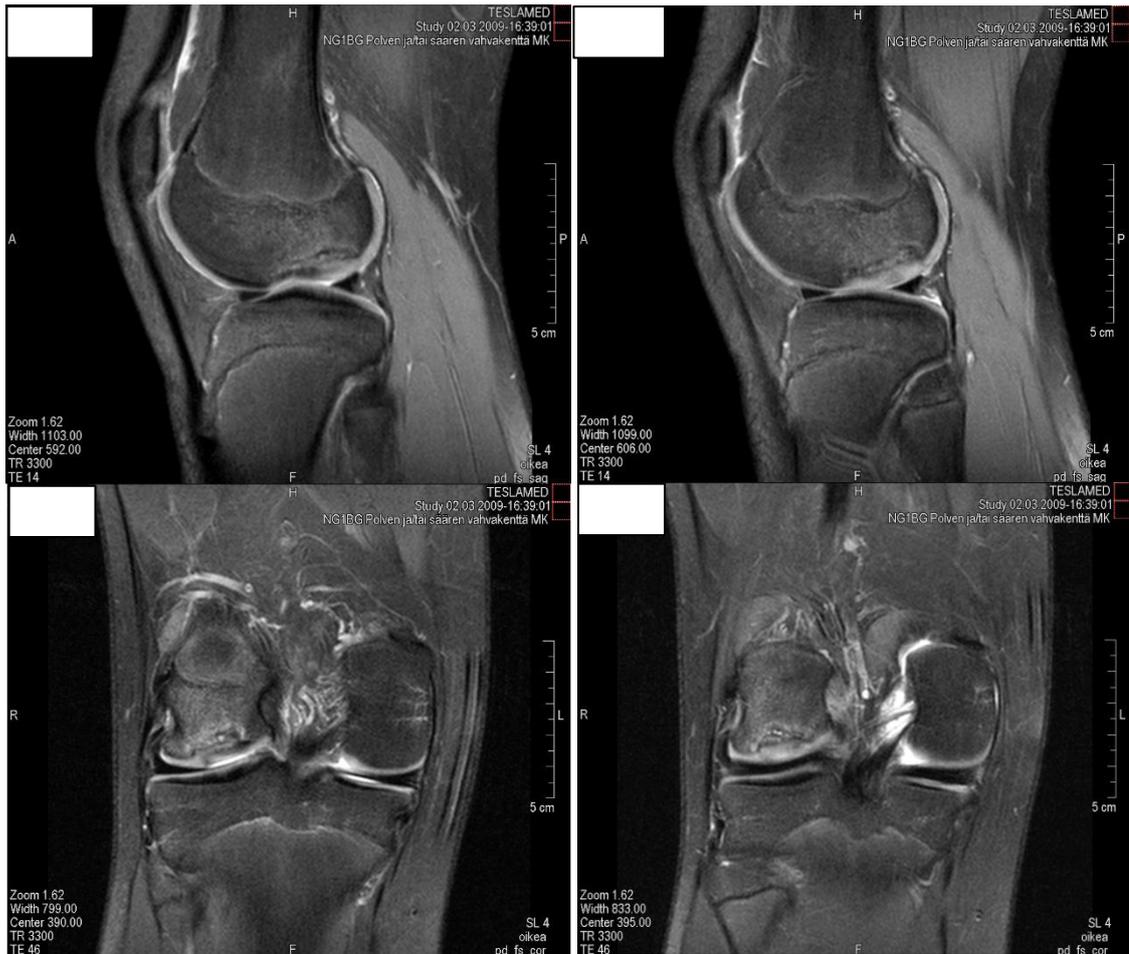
Preoperative MRI of the knee with one OCD lesion on the lateral femoral condyle.
